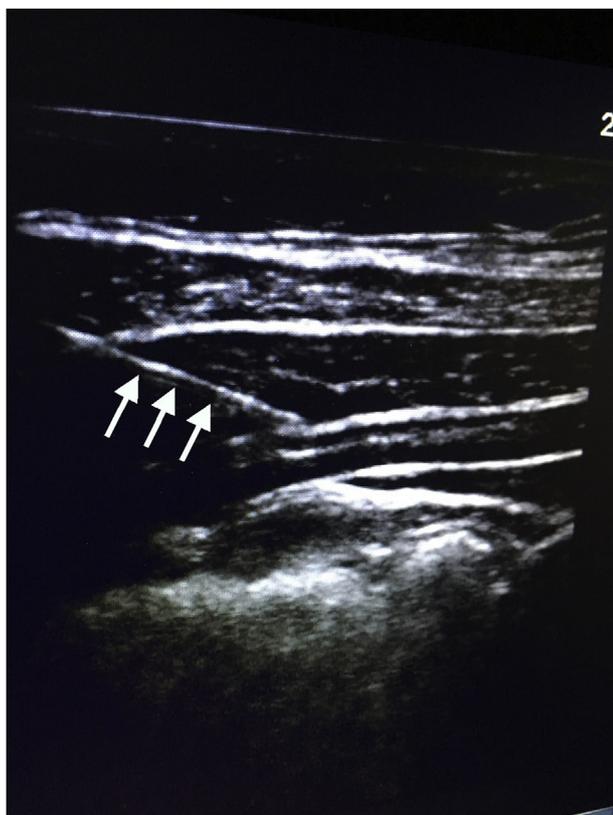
Sonographic view of the needle (arrows), with its tip between the aponeurosis of the internal oblique and transversus abdominis muscles.
